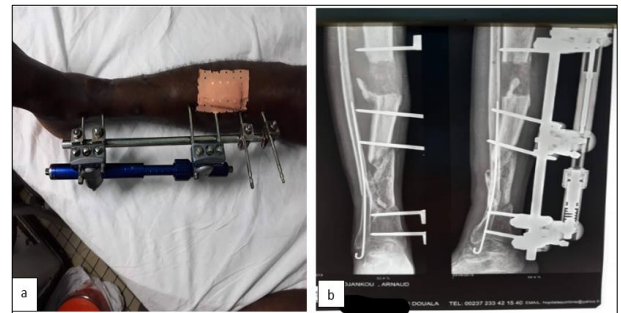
hybrid assembly with a universal AO fixator and a dynamic fixator (a), radiographic control (b)
